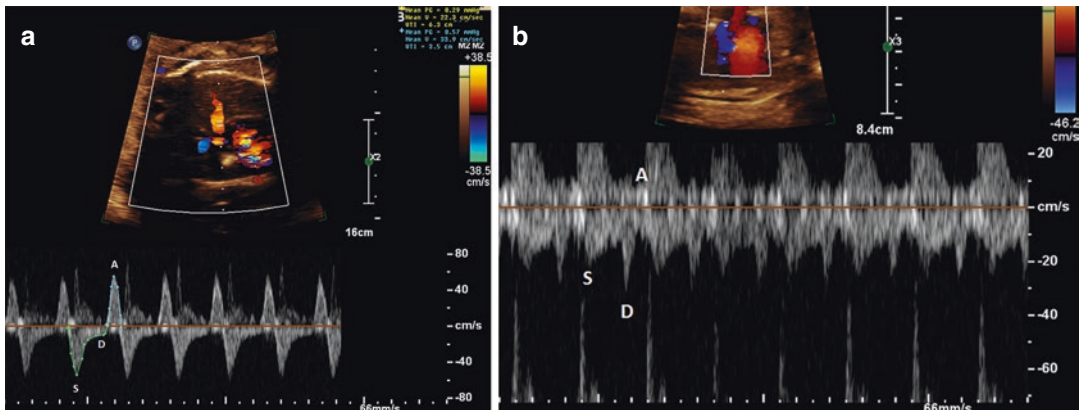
(a) Pulmonary vein PW Doppler in the setting of HLHS with RAS showing decreased forward flow in the pulmonary vein during the systole (S wave) and early diastole (D wave) as well as increased flow during atrial systole (A wave) and prominent A wave reversal. Using a Philips Epiq machine with a C5–1 MHz curvilinear probe. (b) Pulmonary vein PW Doppler showing decreased S and D wave velocities in the setting of fetal cardiomyopathy. Also it is noted the short, peaked D wave suggesting decreased LV compliance (elevated LV end diastolic pressure). Obtained with a Philips Epiq machine with a C5–1 MHz Curvilinear probe
